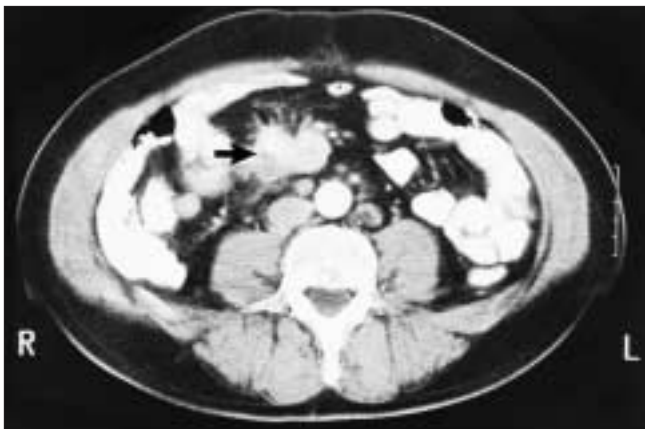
Computed tomography scan demonstrating involvement of mesenteric lymph node (arrow) surrounded by a desmoplastic reaction.
